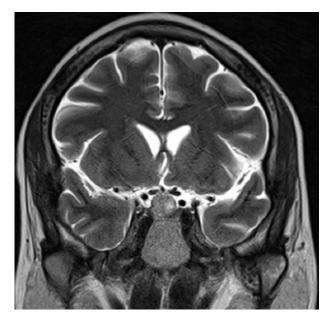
T2-weighted magnetic resonance imaging scan of the brain in a frontotemporal section, showing a well-defined heterogeneously enhancing mass lesion (measuring $15 \times 13 \times 11$ mm) in the sella with mild suprasellar extension. The sella is widened.
